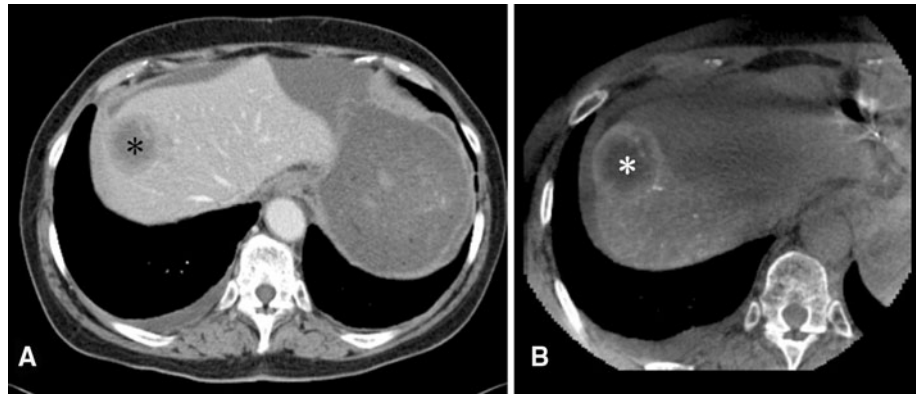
Seventy-one-year old woman with liver metastasis in segment 8 of the liver. C-arm CT shows that the entire tumor can be reached from the right liver lobe artery
